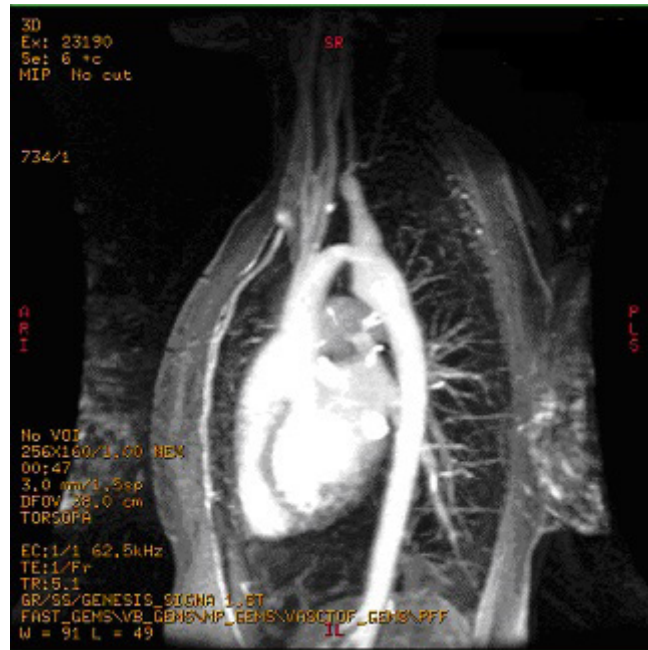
Magnetic resonance imaging showing hypoplasia of the aortic arch and Coarctation of the aorta before the left subclavian artery
